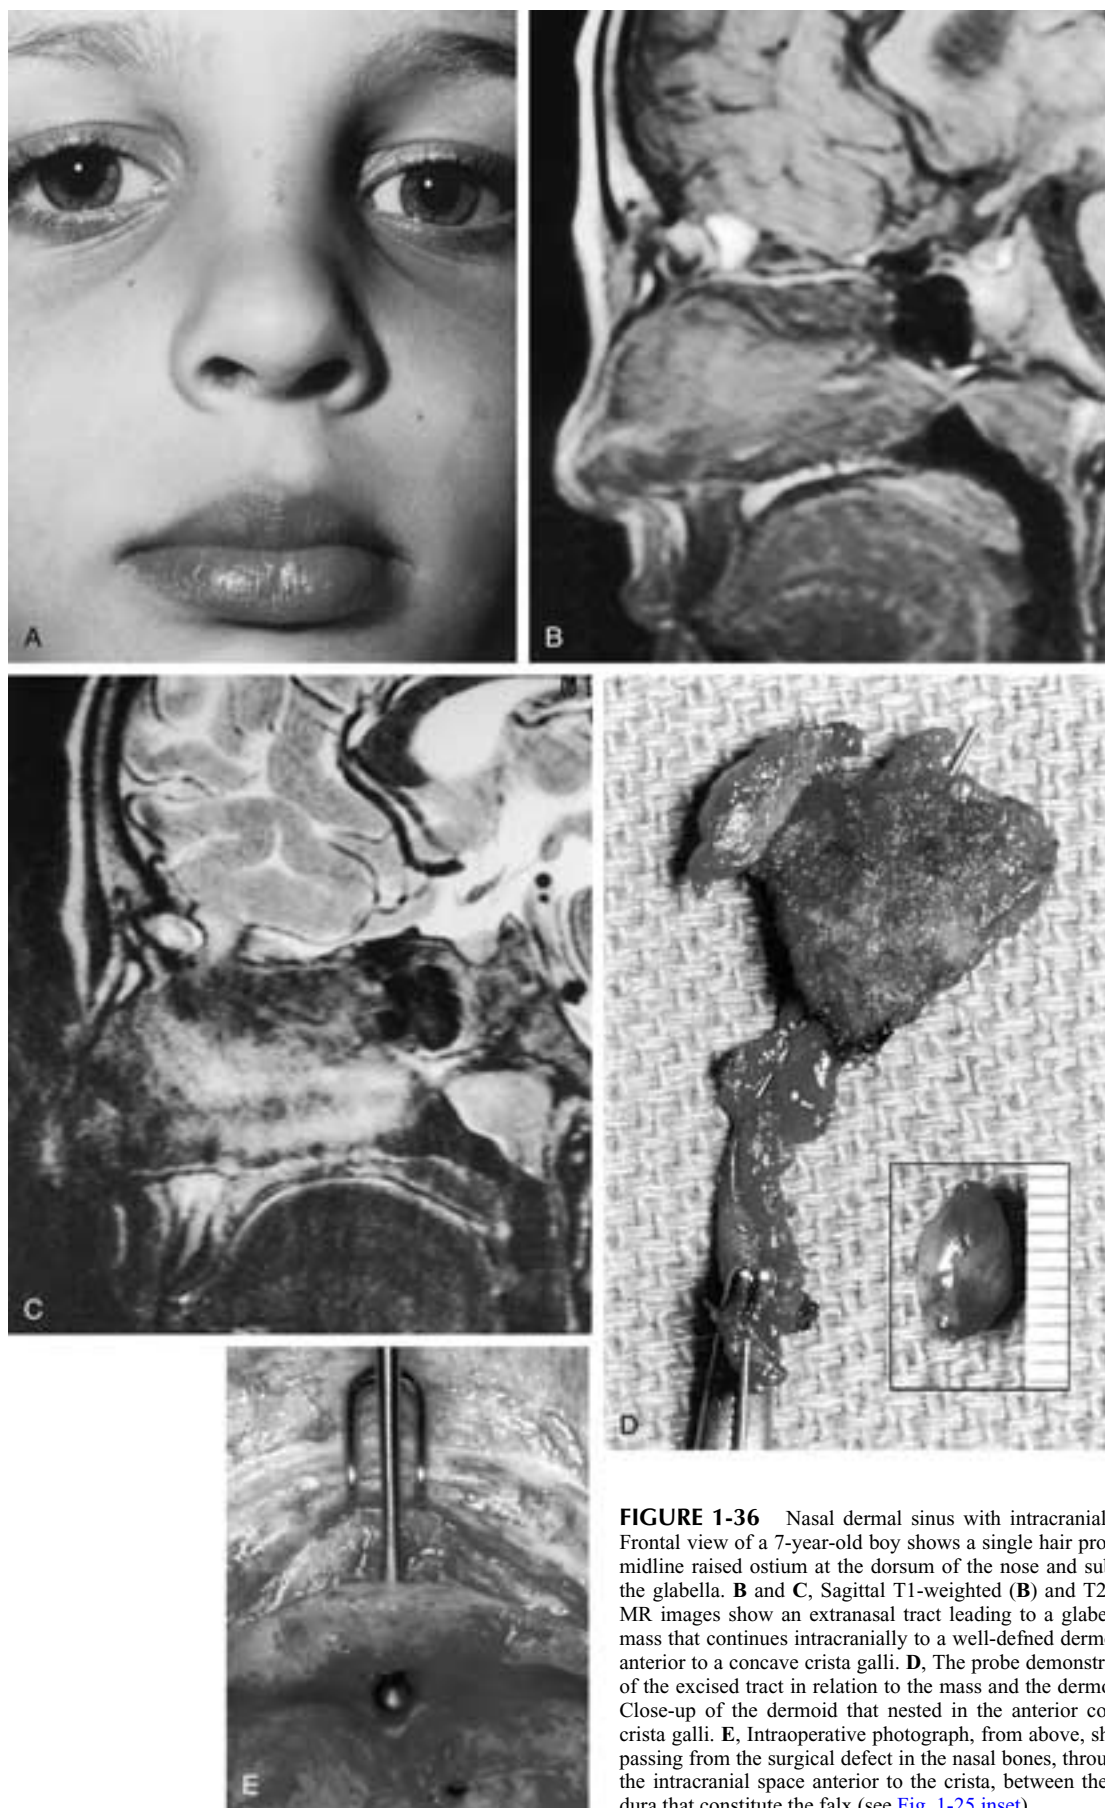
Nasal dermal sinus with intracranial extension. A, Frontal view of a 7-year-old boy shows a single hair protruding from a midline raised ostium at the dorsum of the nose and subtle fullness at the glabella. B and C, Sagittal T1-weighted (B) and T2-weighted (C) MR images show an extranasal tract leading to a glabellar soft-tissue mass that continues intracranially to a well-defined dermoid cyst seated anterior to a concave crista galli. D, The probe demonstrates the course of the excised tract in relation to the mass and the dermoid. *Inset in D*, Close-up of the dermoid that nested in the anterior concavity of the crista galli. E, Intraoperative photograph, from above, shows the probe passing from the surgical defect in the nasal bones, through the tract, to the intracranial space anterior to the crista, between the two layers of dura that constitute the falx (see [Fig. 1-25 inset](#)).
